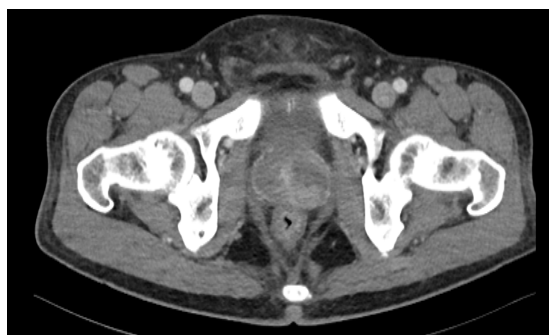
Abdominopelvic CT scan of the patient showing prostatitis with probable abscess formation.
